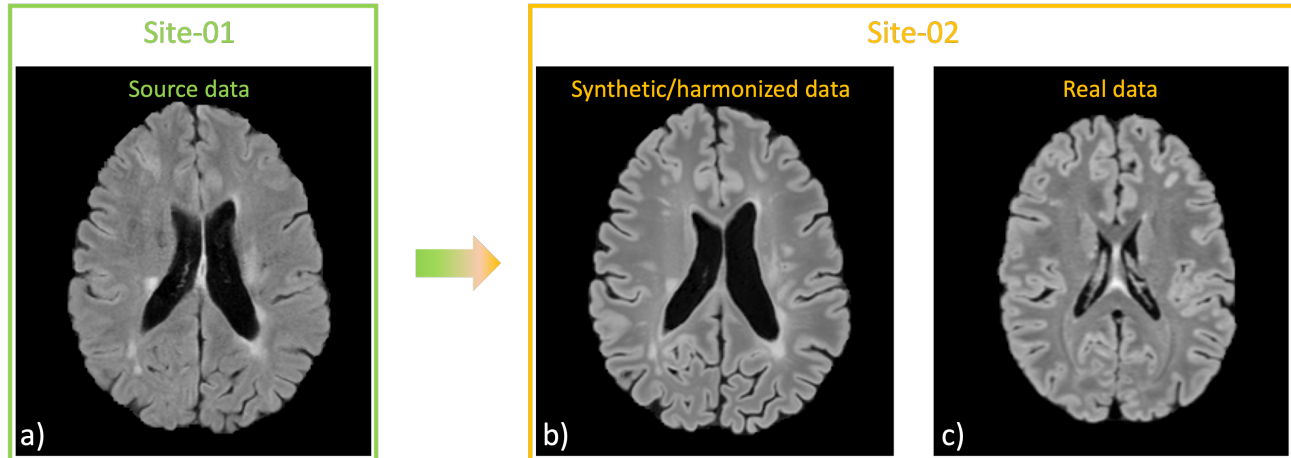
Synthesis-based harmonization of one FLAIR axial slice. (a) Source FLAIR slice from Site-01 (ISBI public training set). (b) Harmonized FLAIR slice from Site-01 matching the contrast of Site-02 (in-house test set) using HACA3.²² (c) Real FLAIR slice from Site-02.
